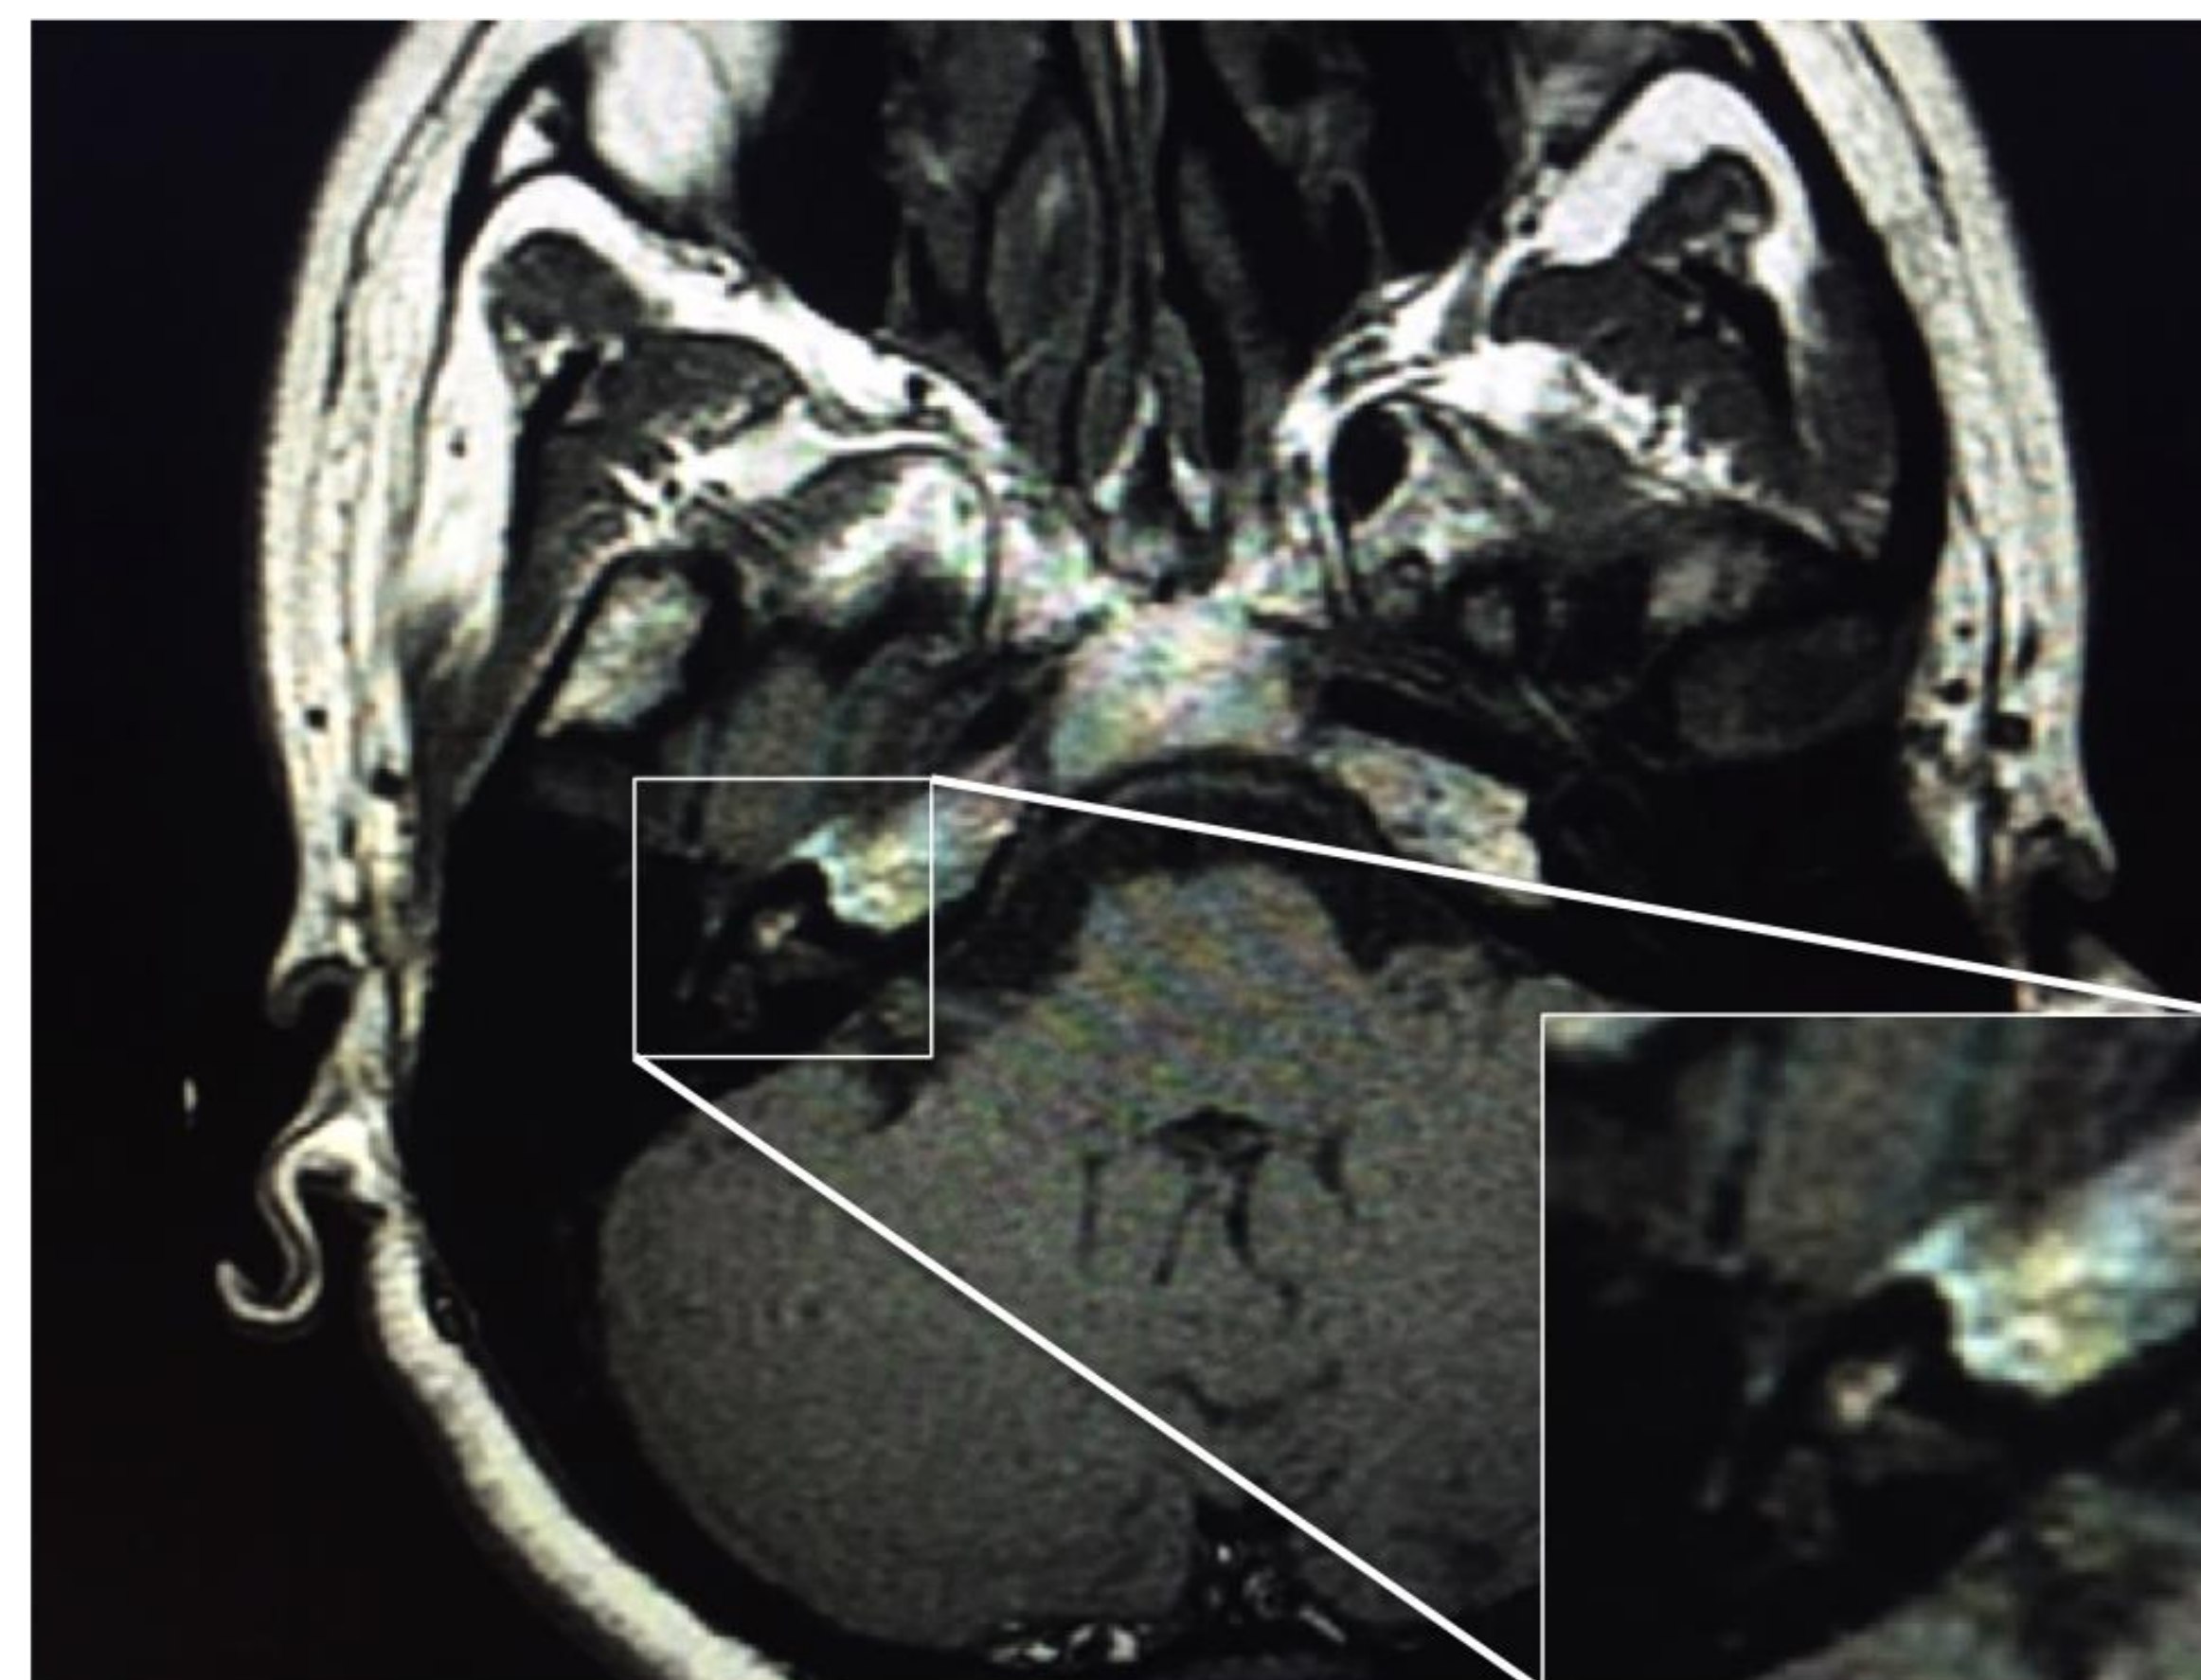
Axial non-contrast MRI T1-weighted pre-gadolinium. Intrinsic hyperintensity can be seen in the right cochlea. An enlarged image of this finding is shown in the lower right corner.
